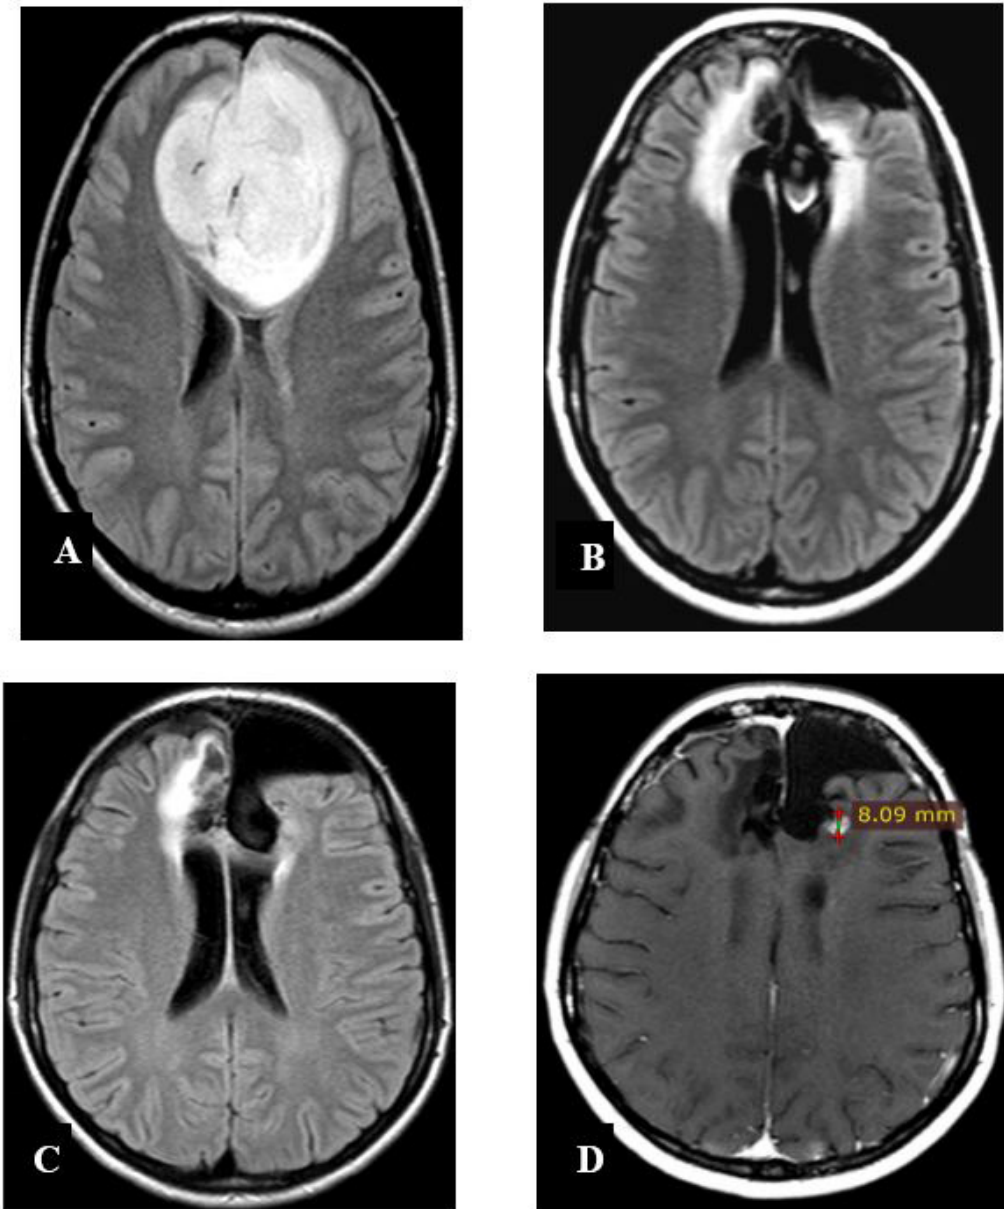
Brain MRI. In A, the diagnostic exam in Sep/2013 with axial FLAIR shows an ill-defined frontal mass that compresses the corpus callosum, measuring approximately 6.1 x 5.7 cm. In B, a follow-up exam was performed in Aug/2014, at the time when the standard treatment with TMZ was withdrawn. In C, an exam in Sep/2019 shows reduction of tumor volume after 5 years of low carb diet combined with intranasal POH. In D, follow-up Axial T1 with contrast exam performed in Jan/2020, the lesion persists with the same dimensions, but the contrast enhancement is less homogeneous.
